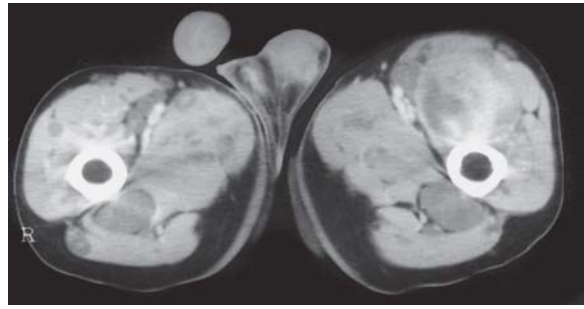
Neurofibromatosis in the proximal thighs of a 23-year-old man. Computed tomography (CT) after iodinated contrast injection. Enhancement of the neurofibrosarcoma in the left anterior thigh. The numerous remaining neurofibromata, particularly involving the sciatic nerves, show no significant enhancement
